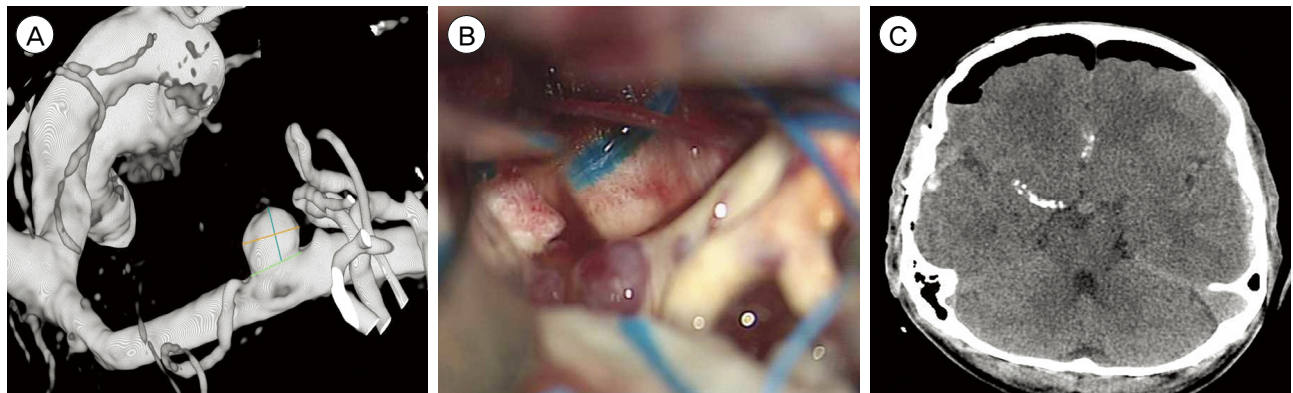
(A) Three-dimensional angiography shows a sacular aneurysm with a 5 mm maximal diameter and 4 mm height at the M1 segment of the right middle cerebral artery (MCA) in a patient with headache. (B) Intraoperatively, the aneurysm has a very shallow aneurysmal height and shows a hemispheric appearance without any definitive neck, in contrast to its initial saccular angiographic finding. The parent artery is severely atherosclerotic along its entire length. Several other hemispheric bulges with thin aneurysmal wall are noted on the ipsilateral MCA. (C) Postoperative computed tomography shows asymptomatic a minimal subdural hematoma on the contralateral side. Diffuse calcification is present along the right middle cerebral and anterior cerebral artery.
